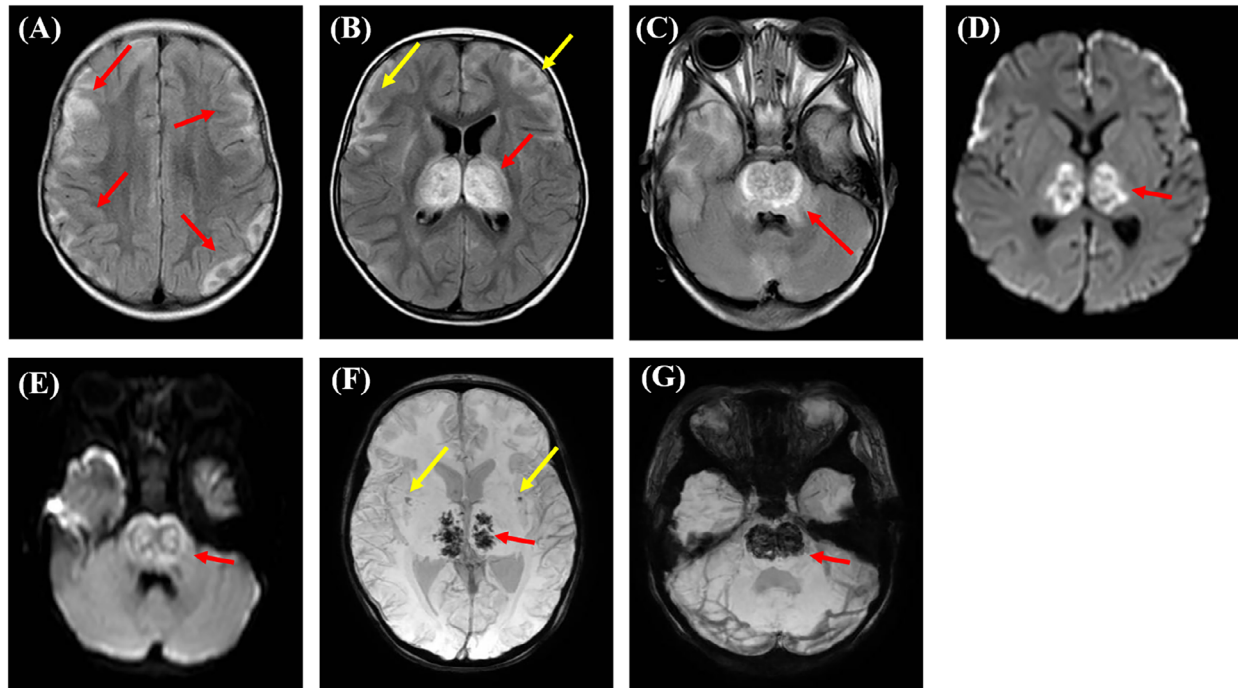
Non-contrast magnetic resonance imaging of acute necrotizing encephalopathy on day 10. (A–C) T2-weighted-fluid-attenuated inversion recovery (T2-FLAIR) showed swelling and increased signal intensity in cortical and subcortical regions of bilateral frontal and parietal lobes (A, red arrows and B, yellow arrows) and symmetrically increased signal intensity in thalami and pons (B and C, red arrows). (D, E) Diffusion-weighted image (DWI) showed increased signal intensity in the bilateral thalami and pons with restricted diffusion and cytotoxic edema (red arrows). (F, G) Hemorrhage was indicated by signal intensity decrease within the insular cortex (yellow arrows) bilateral thalami and pons (red arrows) on susceptibility-weighted images (SWI).
